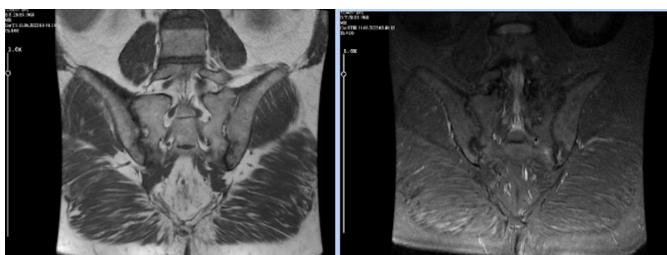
Magnetic resonance images of the sacroiliac joint show the marked narrowing of the inferior sacroiliac joints, increased sclerosis in the surfaces adjacent to the joint, and bone marrow edema on short tau inversion recovery and coronal T1 sections
